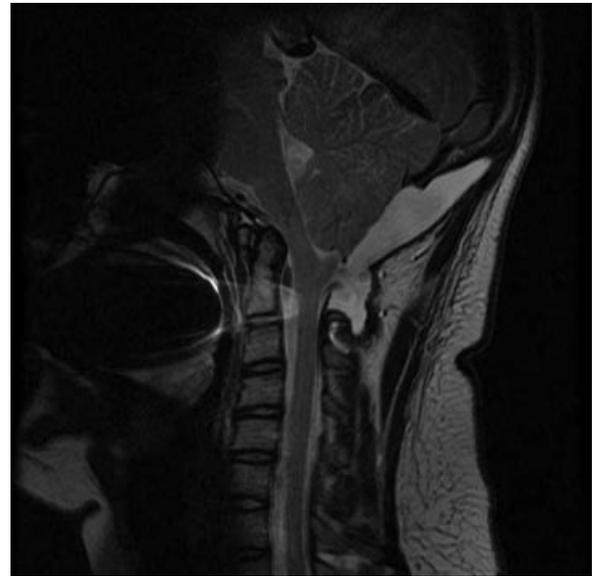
Post-operative sagittal T2-weighted image of the craniocervical junction in the same patient.
